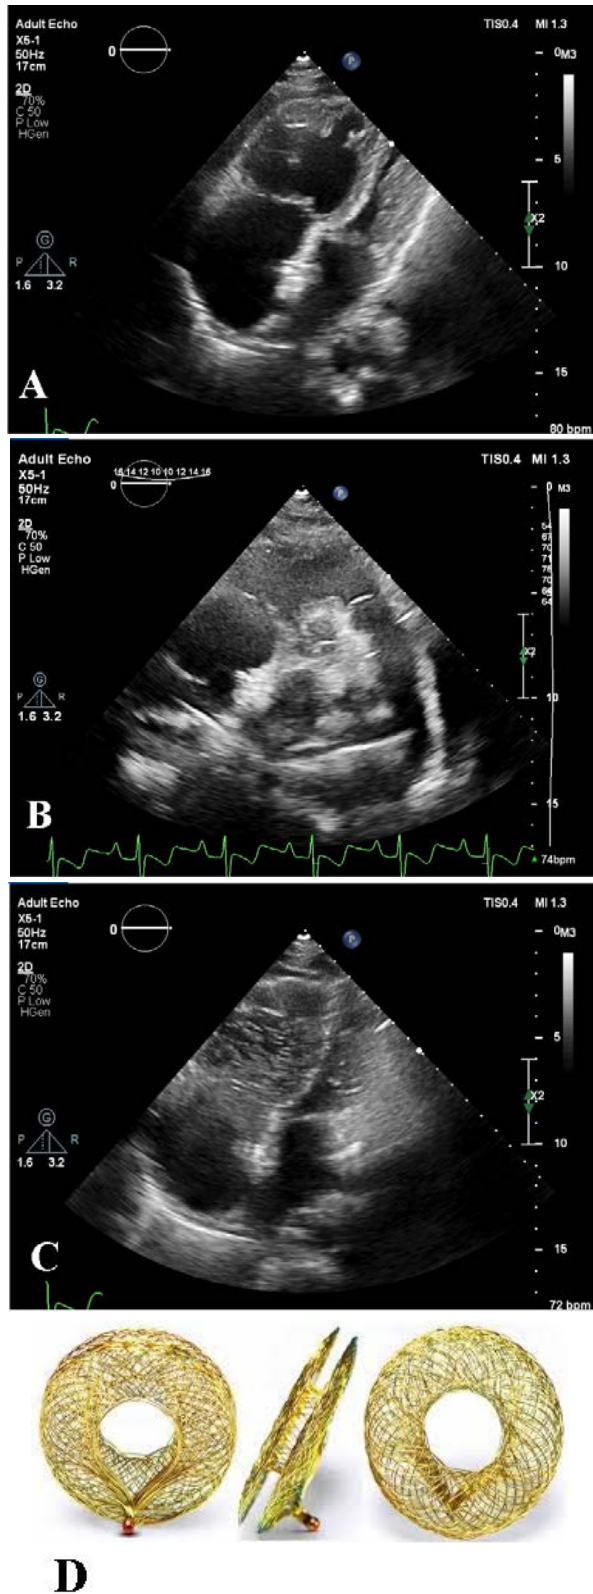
Echocardiography after 6 months follow up with atrial flow regulator (AFR) in inter atrial septum. A) four chamber view, B) short axis view, C) contrast view (arrow shows AFR), D) Occlutech AFR
